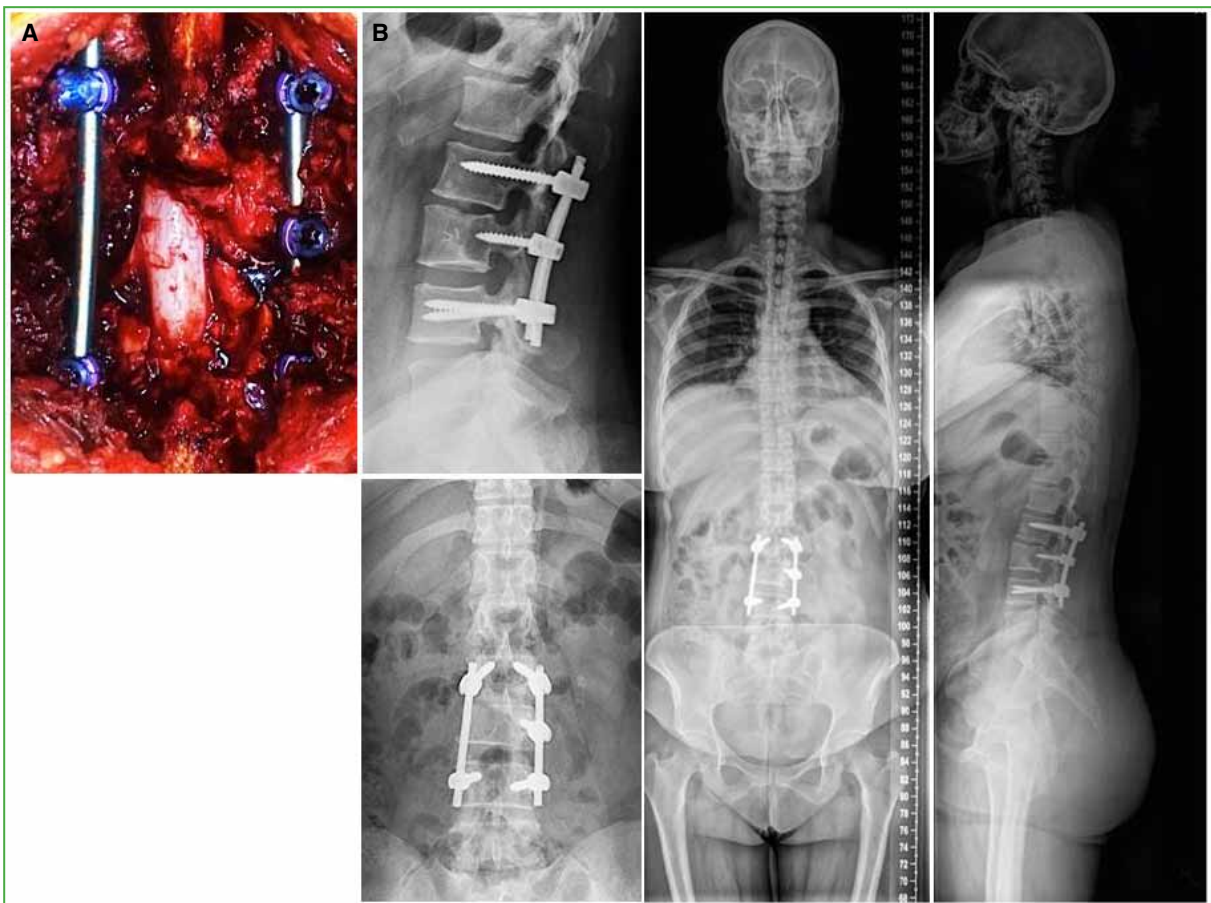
A. Intraoperative image. B. Postoperative radiographs and spinogram.
